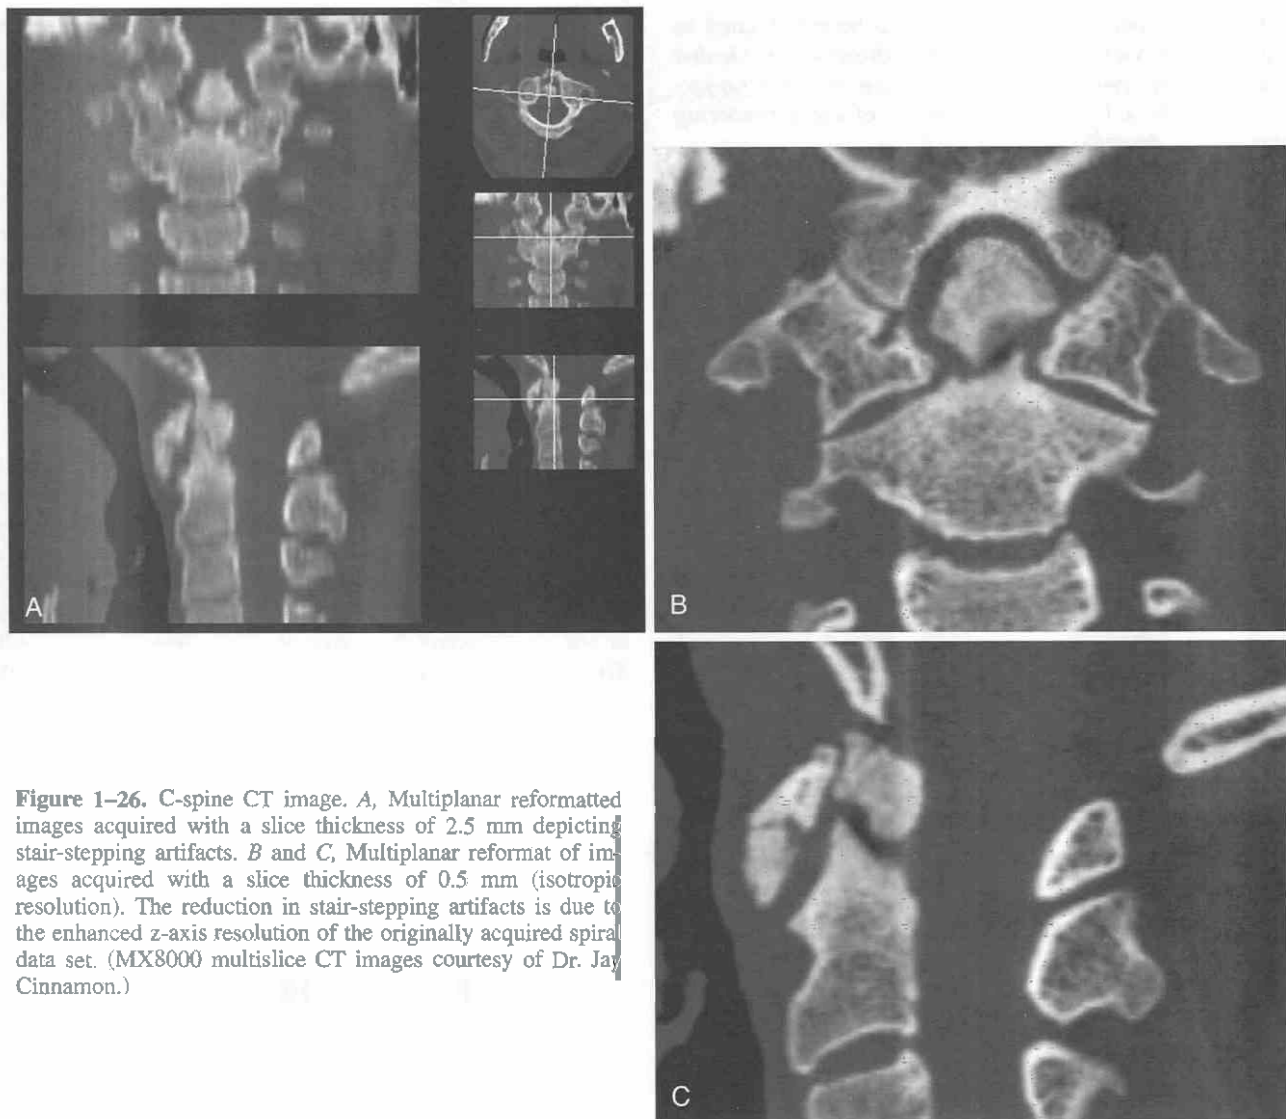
C-spine CT image. *A*, Multiplanar reformatted images acquired with a slice thickness of 2.5 mm depicting stair-stepping artifacts. *B* and *C*, Multiplanar reformat of images acquired with a slice thickness of 0.5 mm (isotropic resolution). The reduction in stair-stepping artifacts is due to the enhanced z-axis resolution of the originally acquired spiral data set. (MX8000 multislice CT images courtesy of Dr. Jay Cinnamon.)
